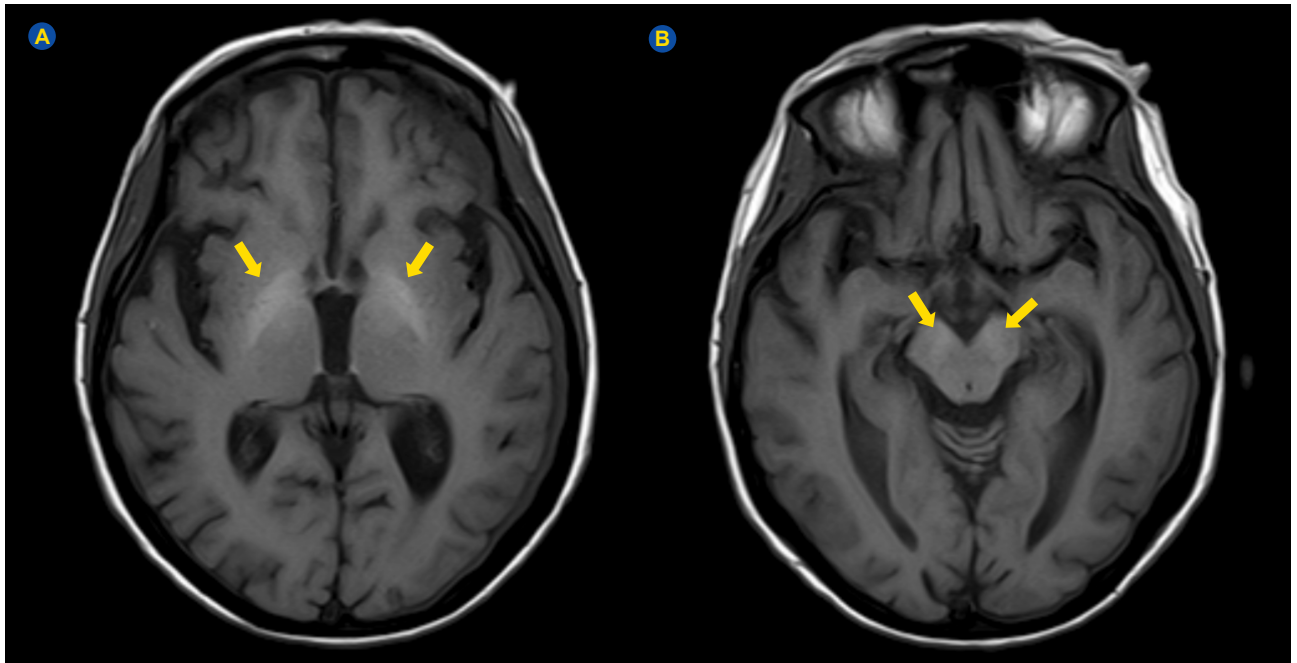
Brain MRI (axial plane) depicted symmetric T1 hyperintensity in *globus pallidus* (A; yellow arrows), *substantia nigra* and mid-brain (B; yellow arrows). These changes are typical of acquired hepatocerebral degeneration, and are believed to be due to manganese deposition in the CNS of patients with chronic hepatic failure.
